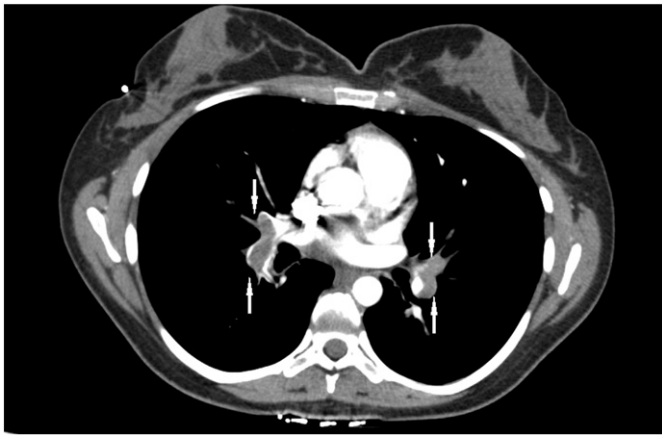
Contrasted Thorax CT showing thrombus in bilateral pulmonary arteries.
